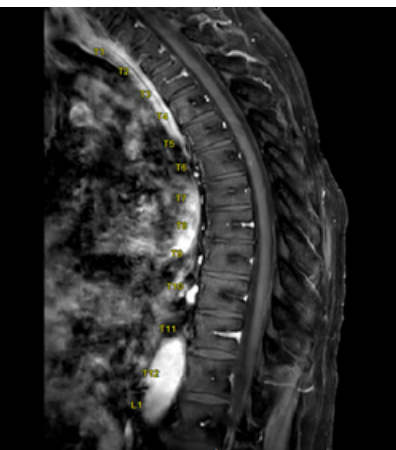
MRI T spine w/wo (T1 sagittal post)
